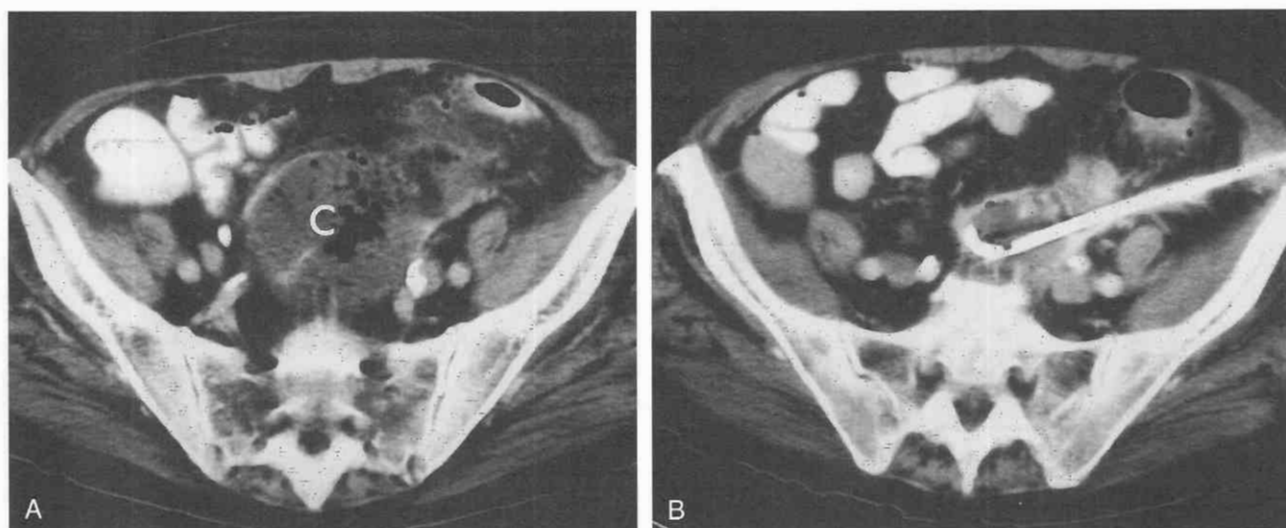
Diverticular abscess. CT scan through a pelvic abscess. *A*, A fluid- and gas-filled cavity (*C*) lies anterior to the sacrum in a patient with known diverticular disease. *B*, After placement of a large-bore drain via a left anterolateral approach.
